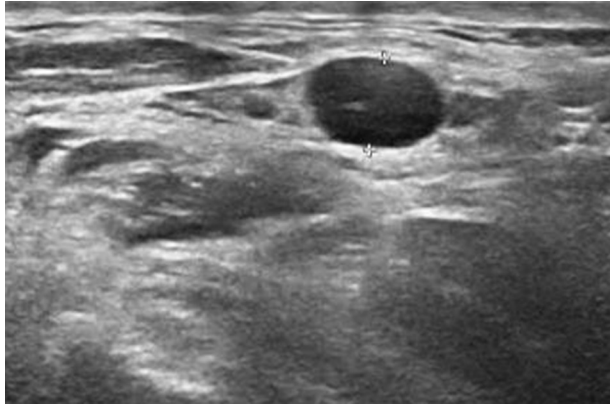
Transverse view of ultrasound of the back of the neck.
